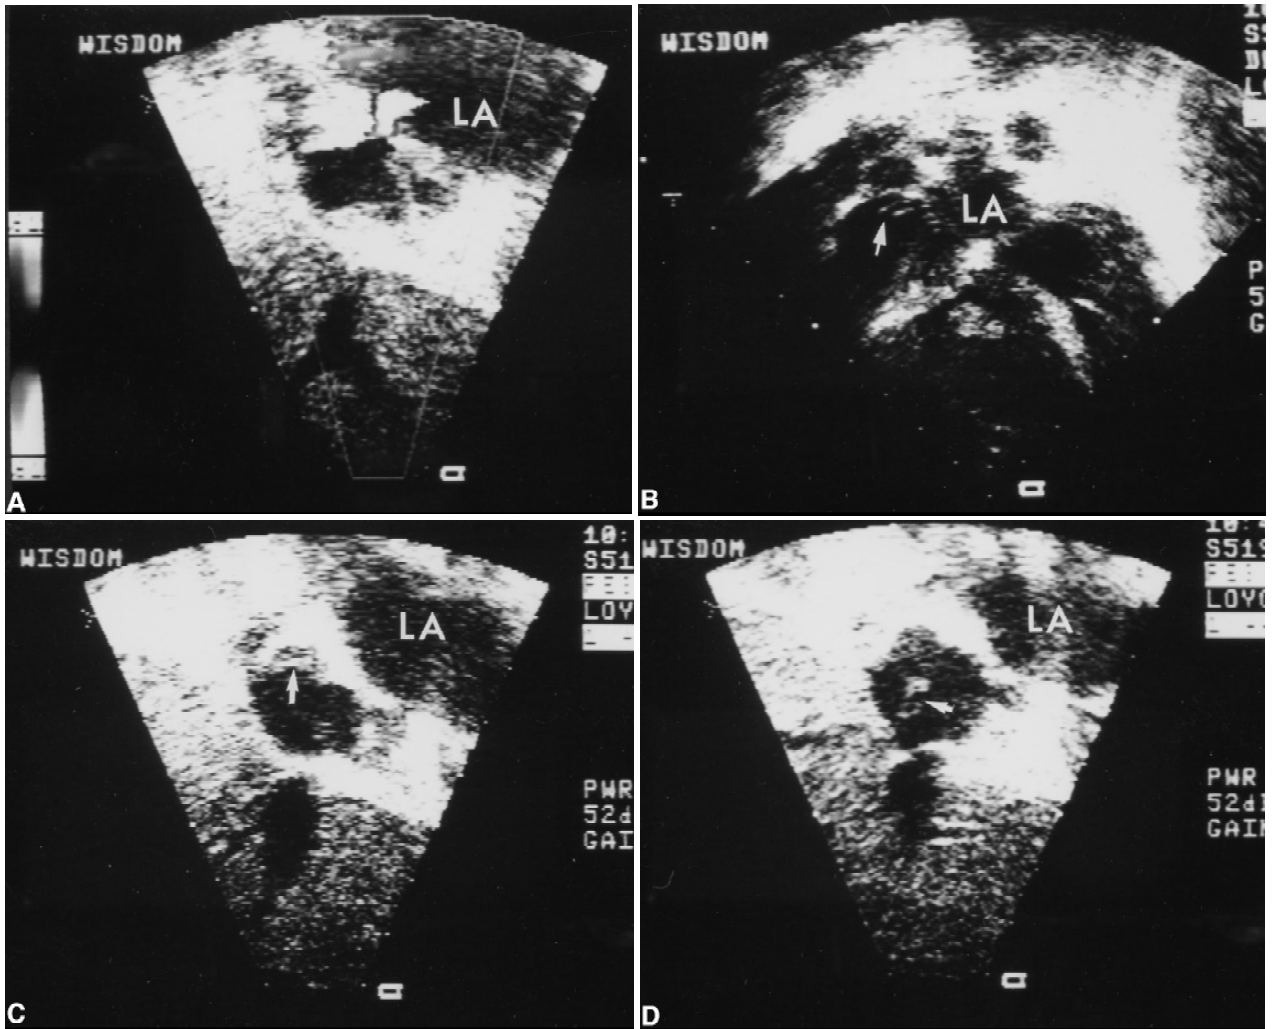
(A) Doppler echocardiogram shows the right-to-left shunt through the atrial fenestration. (B) Sutures for the fenestration (*arrow*). (C) Clot (*arrow*) is attached to the sutures. (D) Another piece of clot, probably an extension of the clot to the right atrium, originates from the sutures. LA, left atrium.
